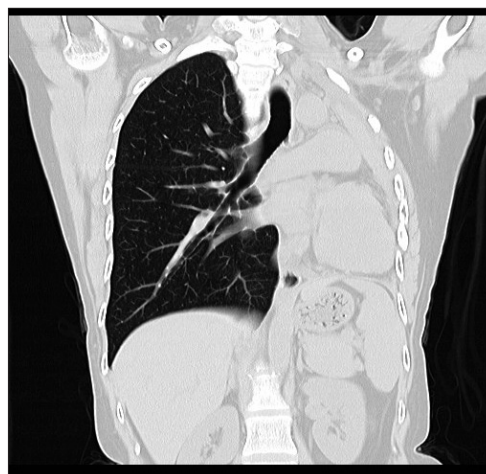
Axial reconstruction of CT Thorax showing complete collapse of the left lung
